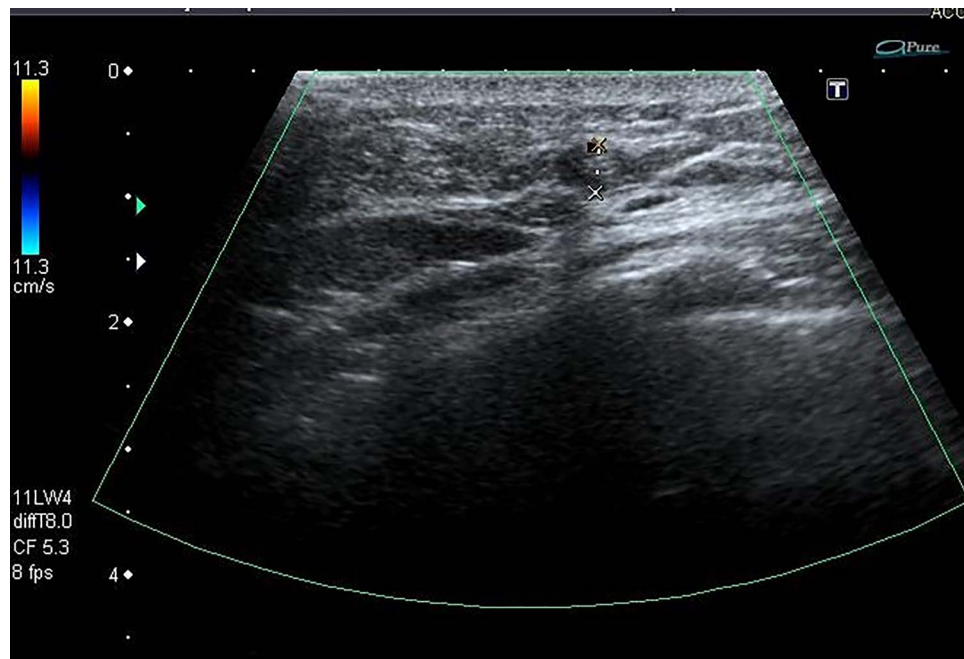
Duplex ultrasound: thrombosed right-sided superficial thoracic vein (transverse view).
